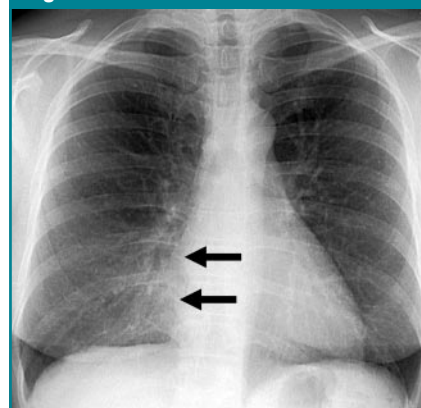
Chest radiograph shows silhouette sign, with obscuration of right border of heart (arrows).
